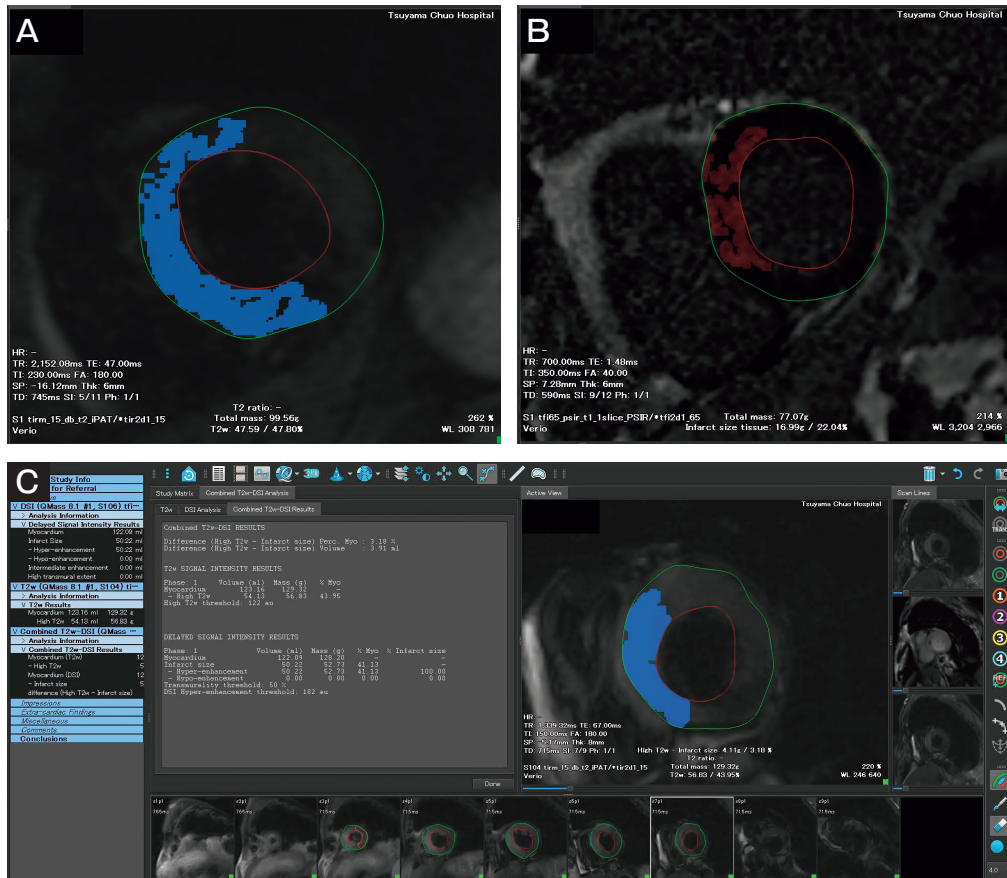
Magnetic resonance imaging (MRI) analysis of the area at risk and infarcted myocardium. MRI short-axis images obtained at the same left ventricular level in a patient in the PROTECTION trial. The MRI was performed at 7 days post-ST segment elevation myocardial infarction (STEMI). A, The area of delayed enhancement (infarcted area, red area in the anterior interventricular septum); B, The area at risk at the same level of the left ventricle (blue area in the interventricular septum); C, Corresponds to panel A after the automatic quantification of the area at risk. Quantification of the infarct was also performed. The area of necrosis was smaller than the area at risk.
